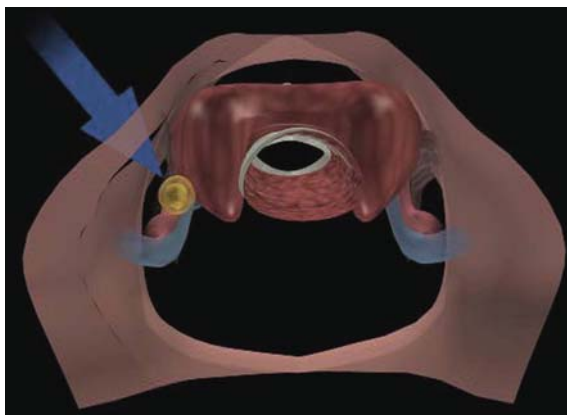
Identification of an inferior parathyroid adenoma via lateral mini-incision technique. The adenoma was localized preoperatively with a functional ^{99m}Tc -sestamibi scan. Immediately prior to incision, the position of the gland was confirmed with surgeon-performed ultrasound and a 2 cm incision was made on overlying skin
